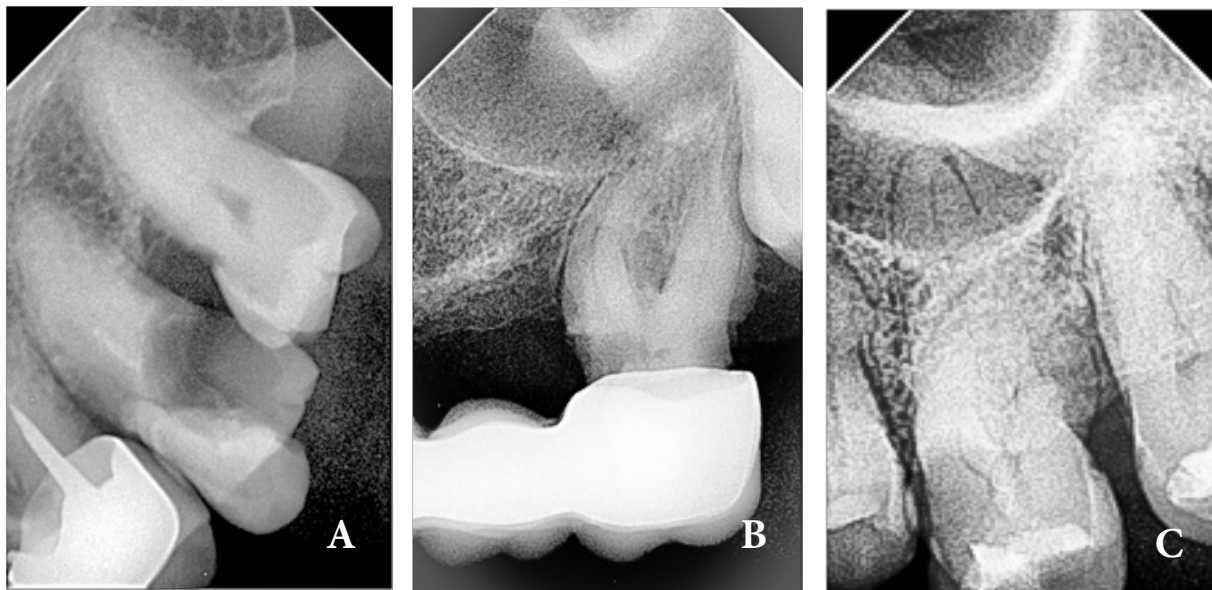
Calcifications shown on intraoral radiographs. A) failed endodontic treatment of the upper left molar due to complete obliteration of the root canal system; B) presence of calcifications in the pulp chamber of the upper left molar, resulting from a mesial carious lesion; C) partial calcification in the pulp chamber, with a completely obliterated distal canal.
